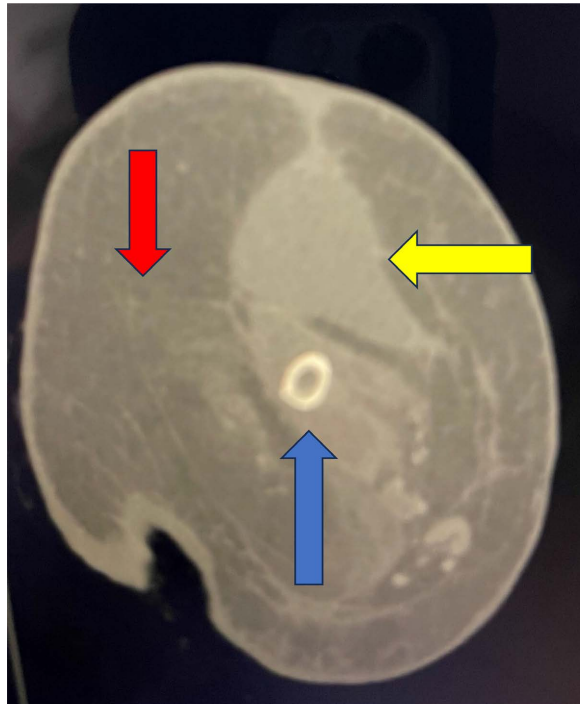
Computed tomography scan (axial view) of right thigh with femoral bone (blue arrow), large abscess (yellow arrow) surrounding the femoral bone, and muscle mass (red arrow).
